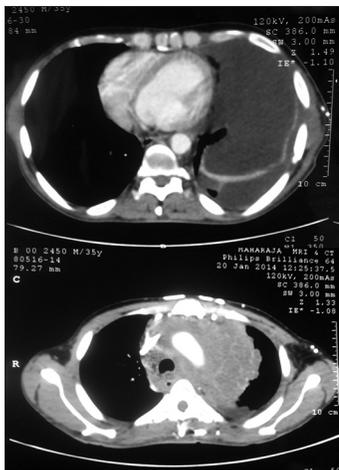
Computed tomography scan showing effusion in left pleural space (top panel) and heterogeneous enhancing soft tissue density mass lesion in left upper lobe extending to whole mediastinum encasing all major vessels (bottom panel)
